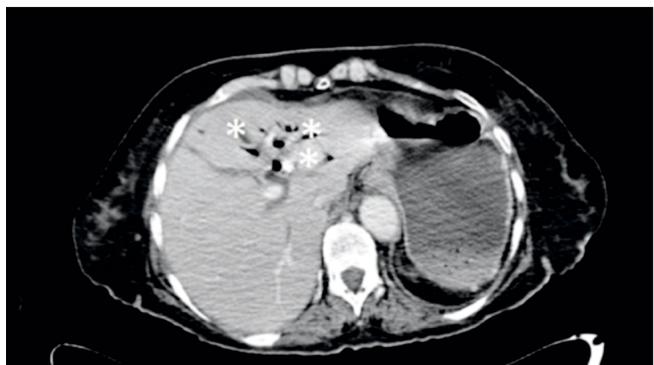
The abdominal computed tomography with intravenous contrast media. The transverse image reveals gas images compatible with portal system (asterisks).
